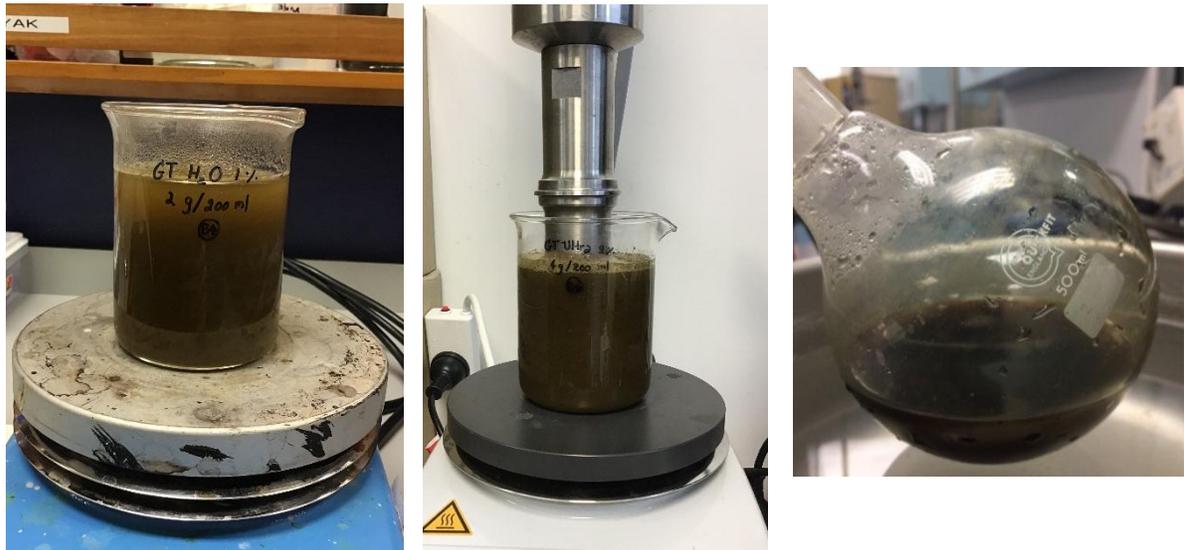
The green tea waste mixture extracted by hot water (Left), ultrasound-assisted (Middle), and ethanol (Right) extraction methods. The hot plate (Left and middle) and water bath (Right) were applied to increase the mixture temperature in order to achieve the target temperature. A digital thermometer was used to monitor the temperature.
